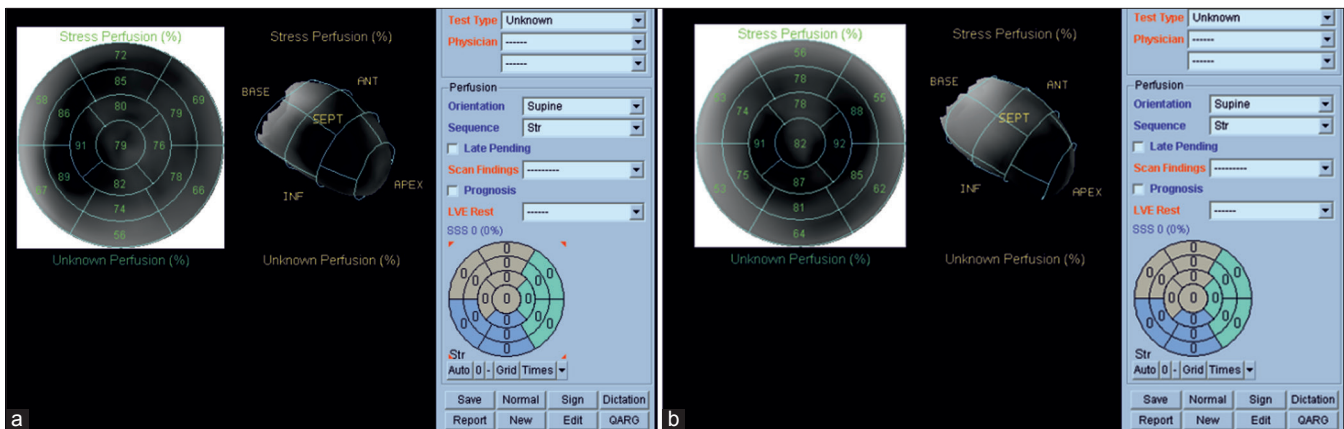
(a) An example of Bull’s eye segments of the patient with S/L ratio >1 in myocardial perfusion scintigraphy. The values obtained from echocardiography were as follows: IVSd = 13 mm, LVPWd = 12 mm. (b) An example of Bull’s eye segments of patient with S/L ratio <1 in myocardial perfusion scintigraphy. The values obtained from echocardiography were as follows: IVSd = 10 mm, LVPWd = 9 mm
